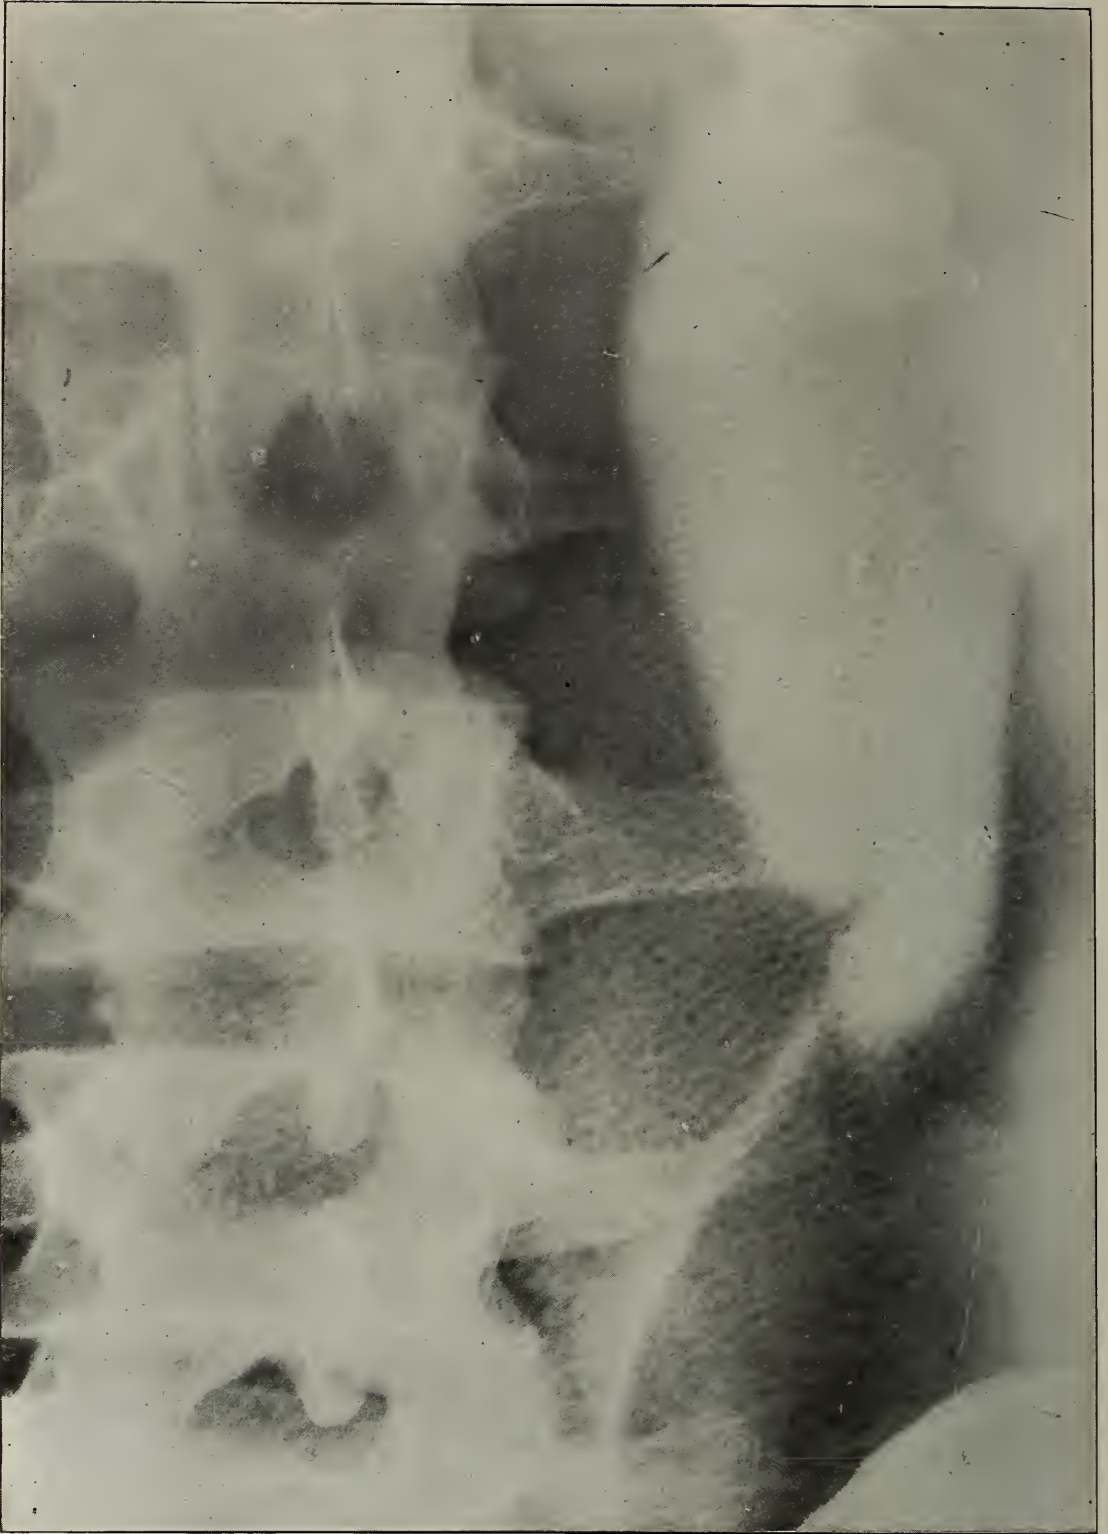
X-ray No. 10317. Region: left lumbar. A large hydronephrosis. A suspicious shadow in line of right ureter indicated cystoscopic examination and this led to finding of the hydronephrosis. At operation an anomalous vessel was found constricting the ureter.
